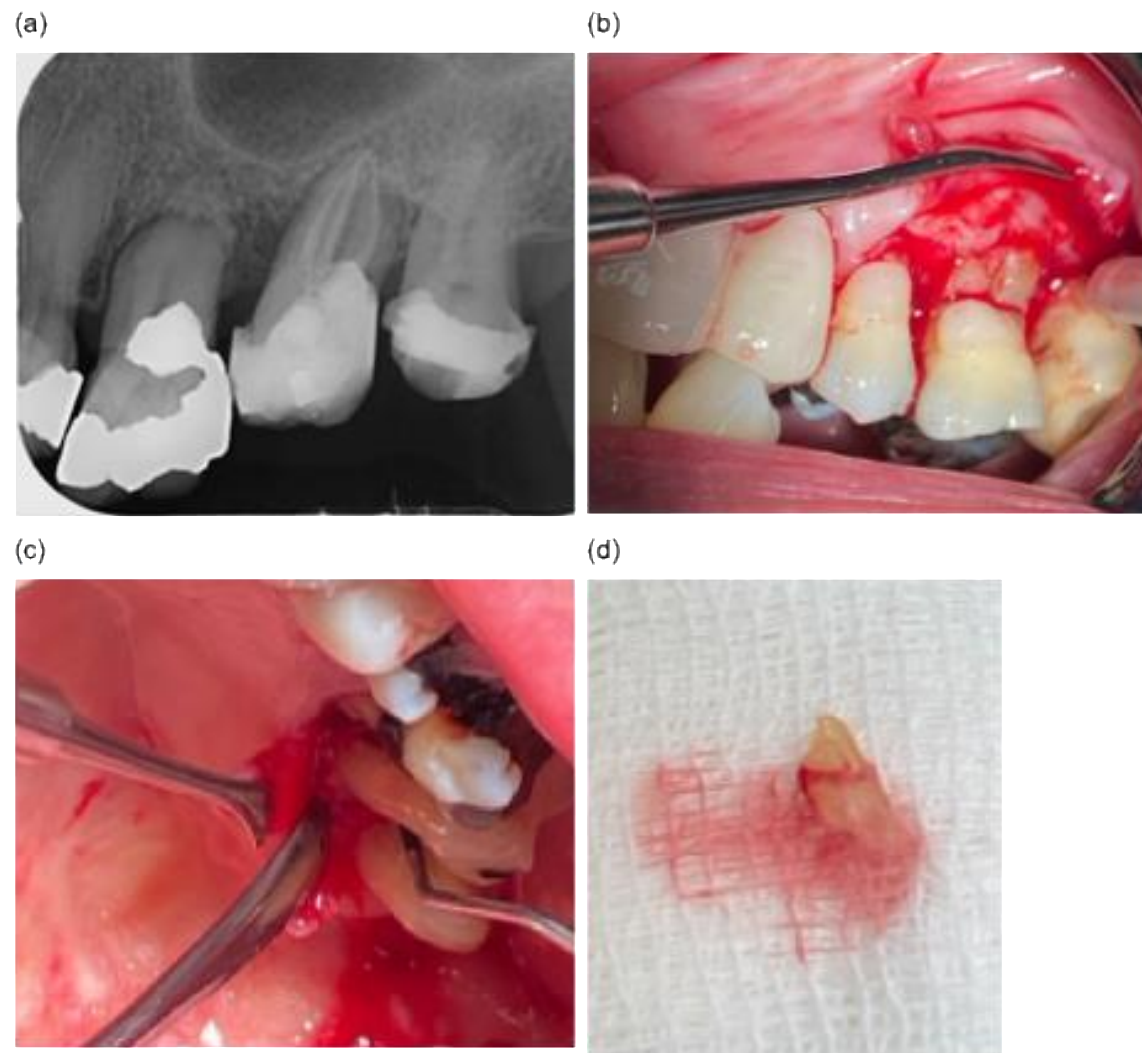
Intraoral periapical radiograph of obturated tooth 27, (b) mucoperiosteal flap elevation (c) class II furcation involvement of distal tooth 27 (d) resected distal root of tooth 27.
